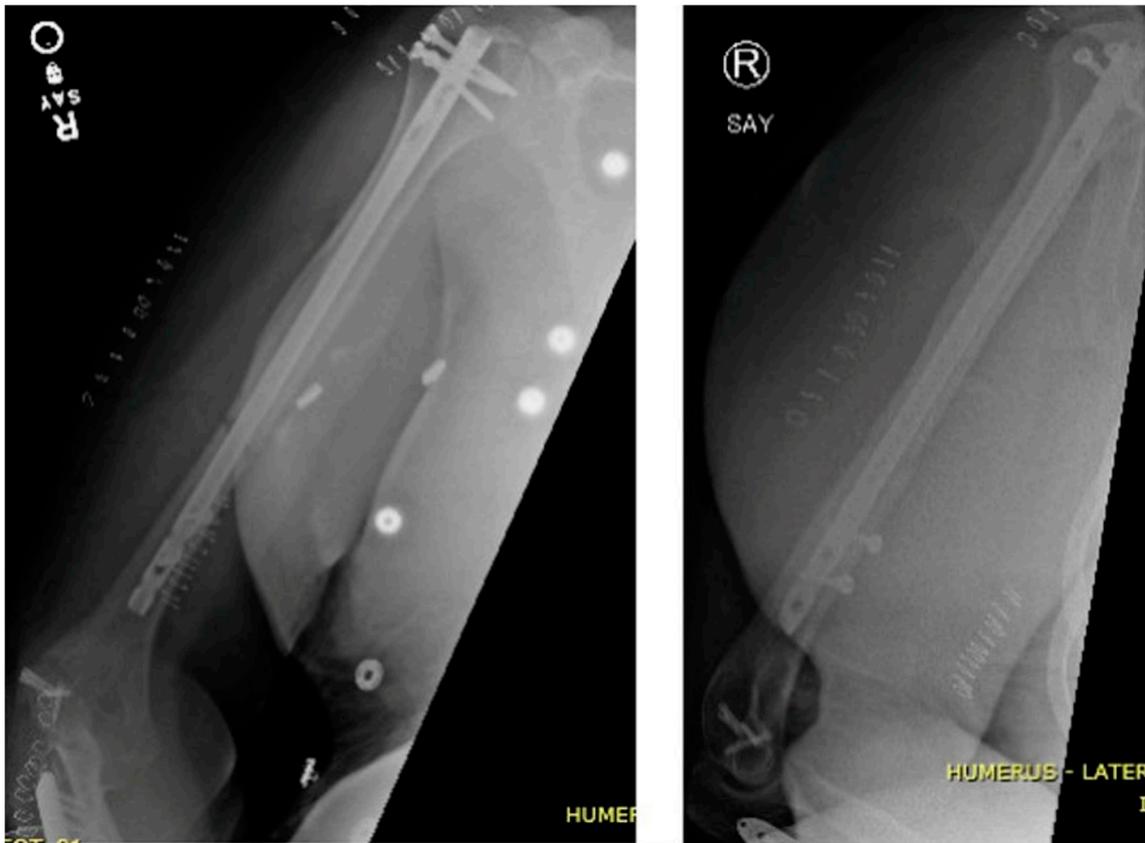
AP and lateral radiograph of right humerus demonstrating reduction and fixation postoperatively.
